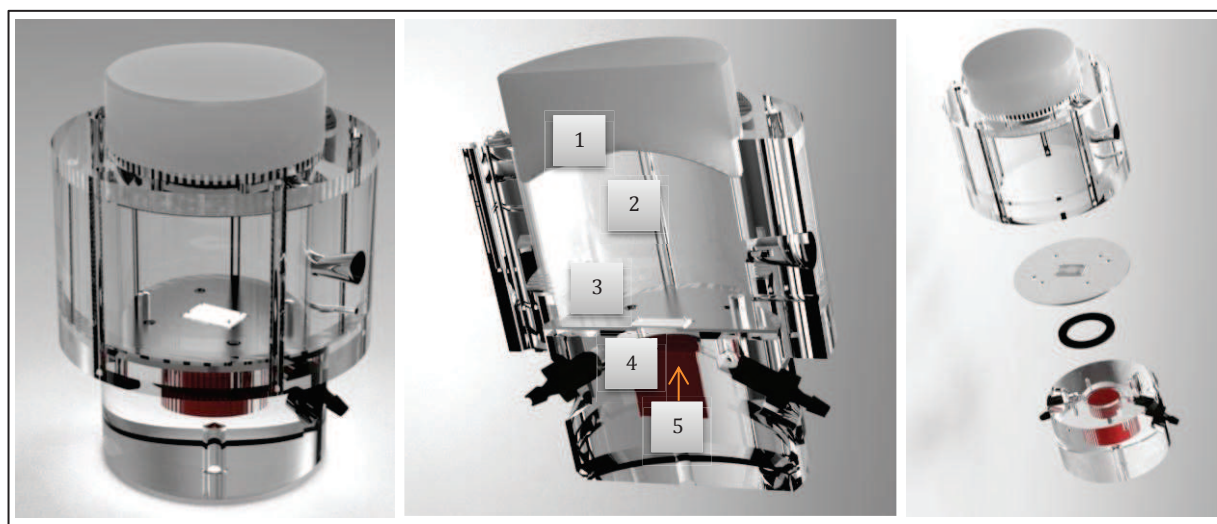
Custom diffusion cell. (1) US transducer; (2) donor chamber; (3) tissue membrane; (4) receiver chamber; (5) ultrasonic absorber.
